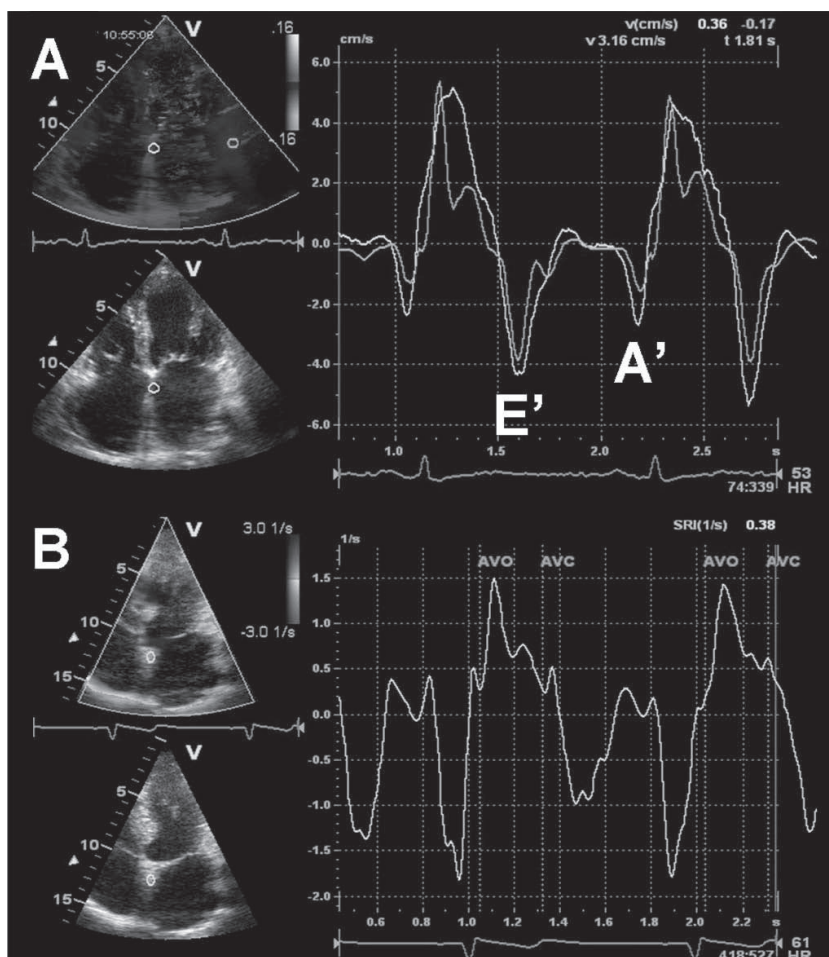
Panel A: Color-coded tissue Doppler imaging in the apical 4-chamber view for the assessment of regional LA function. The samples are placed in the basal atrial septum and the basal atrial lateral wall. From the myocardial velocity curves, peak systolic and diastolic velocities can be assessed. Early diastolic filling is indicated by E' and late diastolic filling is indicated by A'. Panel B: Strain rate imaging in the apical 4-chamber view in a patient with a history of paroxysmal atrial fibrillation. A sample is placed in the basal atrial septum. From the time-strain curves segmental atrial contraction and time-to-peak strain can be derived. The vertical green lines indicate aortic valve opening (AVO) and aortic valve closure (AVC).
